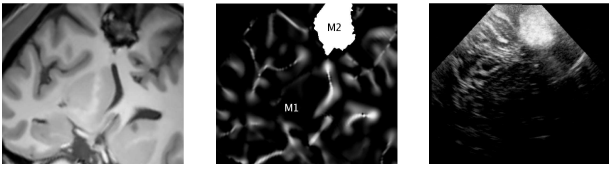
Left : the denoised MR images. Middle : the probability map based on $MLvv$ and tumor segmentation. Right : the corresponding US images obtained with the registration provided by the neuronavigation system.
